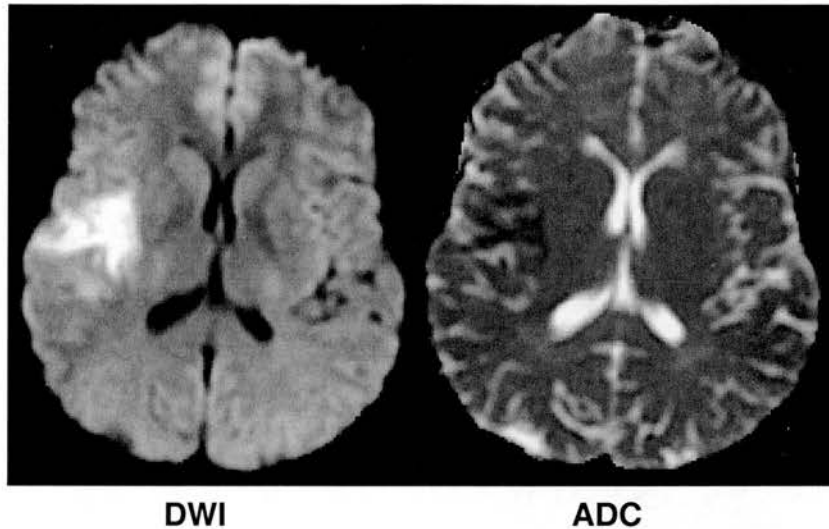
DWI and ADC images from a patient with a right hemisphere ischaemic lesion at 6 hours after stroke onset. Note the hyperintense DWI lesion is easily visible, while the hypointense ADC lesion is less easily distinguished (particularly at the lesion edges).
